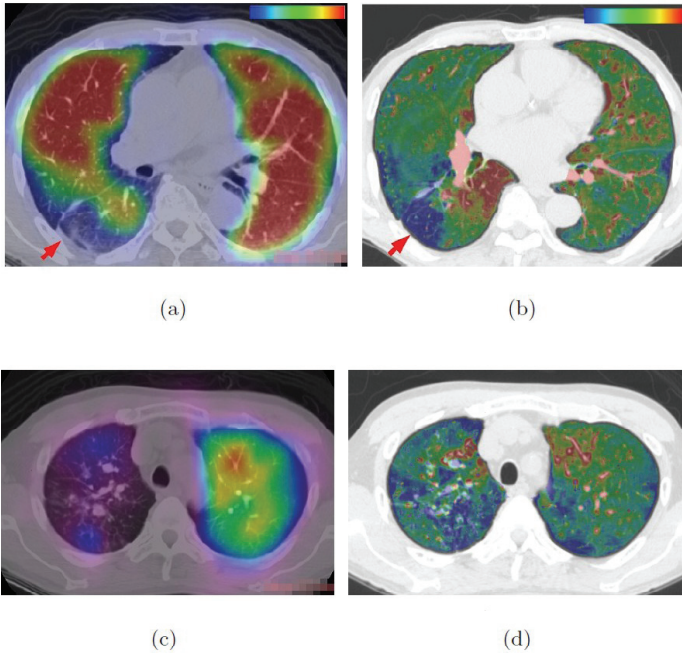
Examples of the color-coded subtraction images that show low blood flow in parenchyma region. (a) and (c) are RI-SPECT images manually registered on the corresponding CT images. (b) and (d) are the subtraction images produced by our system.
